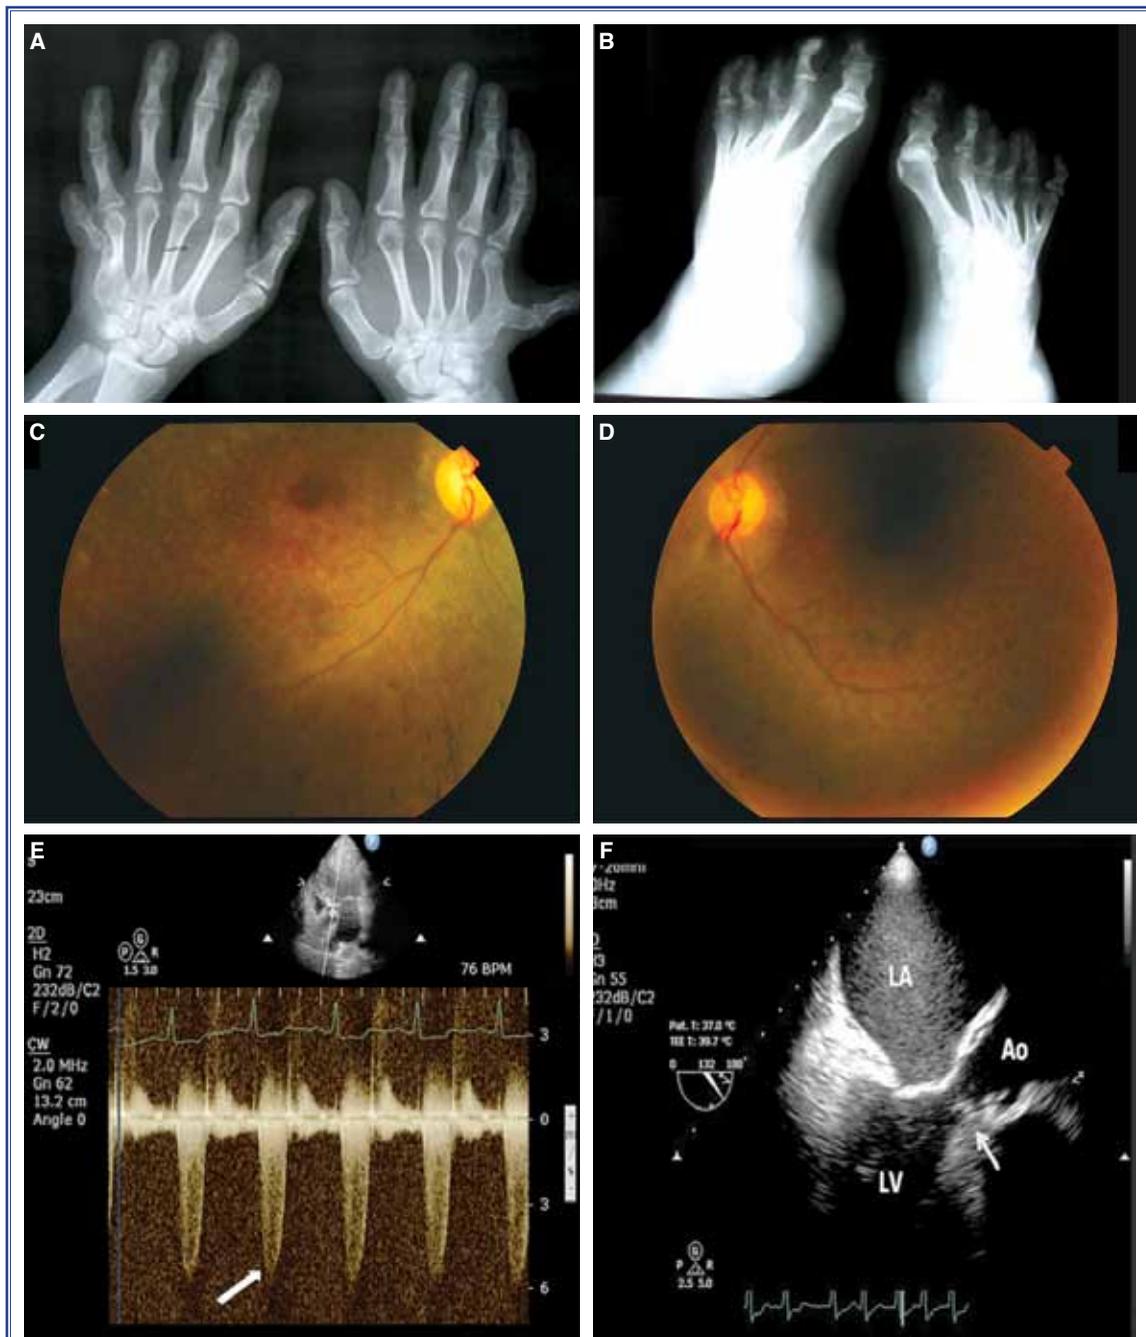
Polydactyly in (A) upper limbs and (B) right lower limb. Retinitis pigmentosa in (C) right and (D) left eyes. (E) High LV outflow velocity in apical five-chamber view in transthoracic echocardiography (white arrow), (F) subaortic discrete membrane in transesophageal echocardiography (white arrow).
